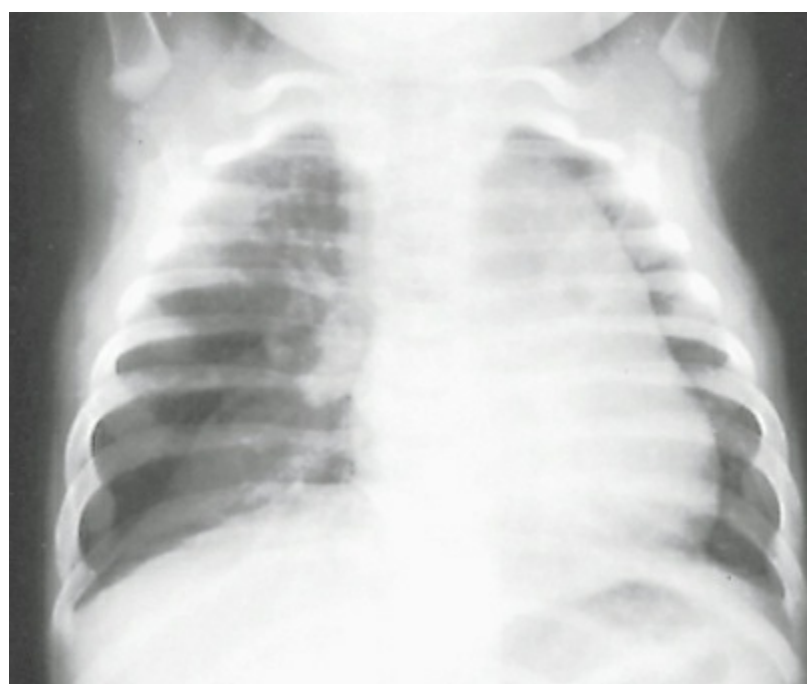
Radiograph of a newborn with lobar emphysema involving the right middle lobe. Note the compressed right lower lobe and mediastinal shift. (Reproduced with permission from Shields TW, ed. *General Thoracic Surgery*. 6th ed. 2005.)
